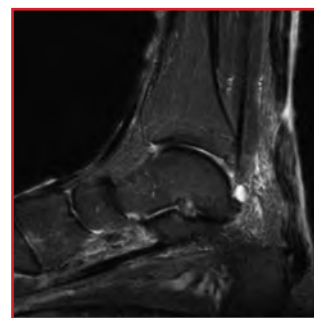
Magnetic resonance imaging of the right ankle at 9 days after initial injury, showing rupture of the right Achilles tendon.
